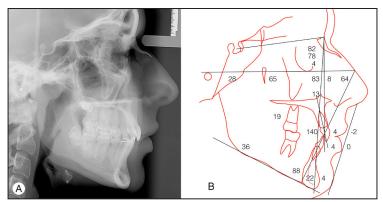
A. Lateral cephalometric radiograph, B- Cephalometric tracing and measurements (at age 14 years and 4 months)
